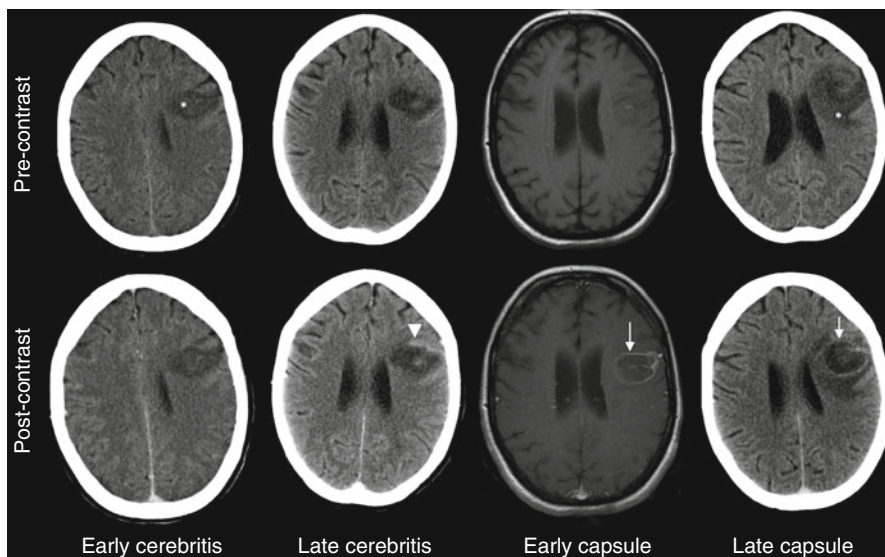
Stages of abscess formation. CT and MR examinations of one patient showing the evolution of cerebritis into abscess over time. *Top row* – unenhanced images; *Bottom row* – post-contrast images. Non- or poorly enhancing hypodensity (*) represents early cerebritis. In late cerebritis, there is some ring-like enhancement (*arrowhead*). The enhancing capsule is evident in the early capsule phase (*arrow*) with hyperintense contents of the lesion. On CT, there is oedema surrounding the lesion (*) as well as persistent ring-enhancement (*arrow*) in the late capsule phase
